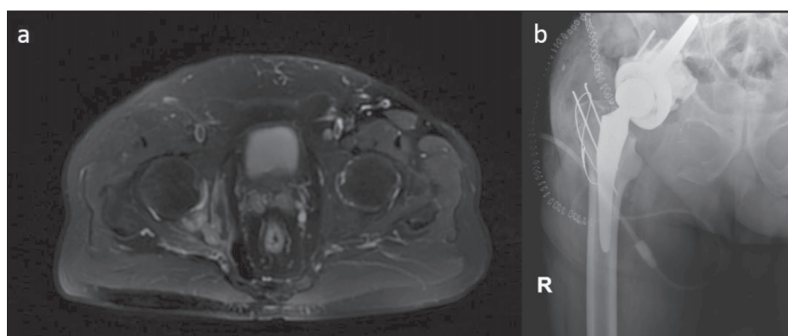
Case 17: a 73-year-old male with a metastatic lesion at right posterior acetabulum due to lung metastasis; a – magnetic resonance imaging; b – X-ray view after periacetabular resection and endoprosthetic reconstruction
